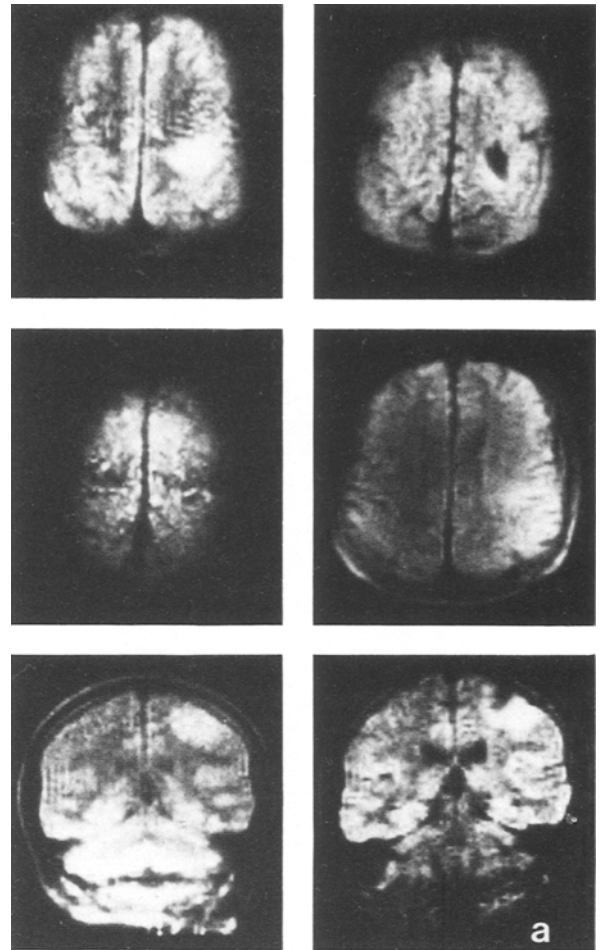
See Fig. 5. MRI findings pre- and post-operatively (a), cortico- und subcorticography with bioelectrical silence (Channel 11) inside the tumour with "normal tissue" (b)
